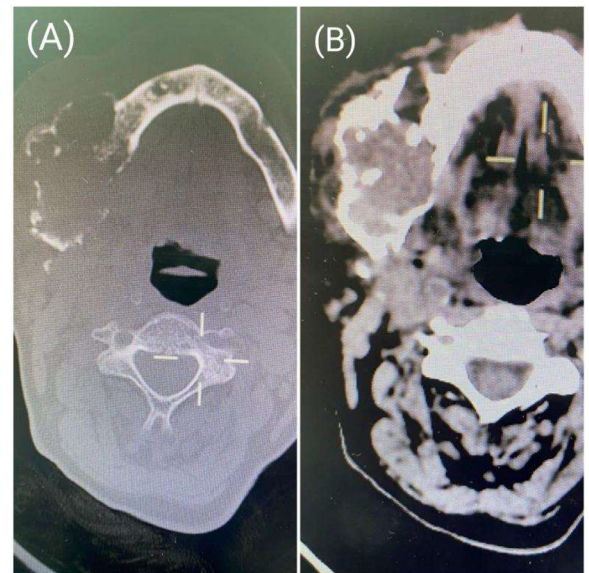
Axial CT scan view showing an osteolytic lesion of the mandible with cortical bone destruction (A) bone window (B) soft tissue window.
